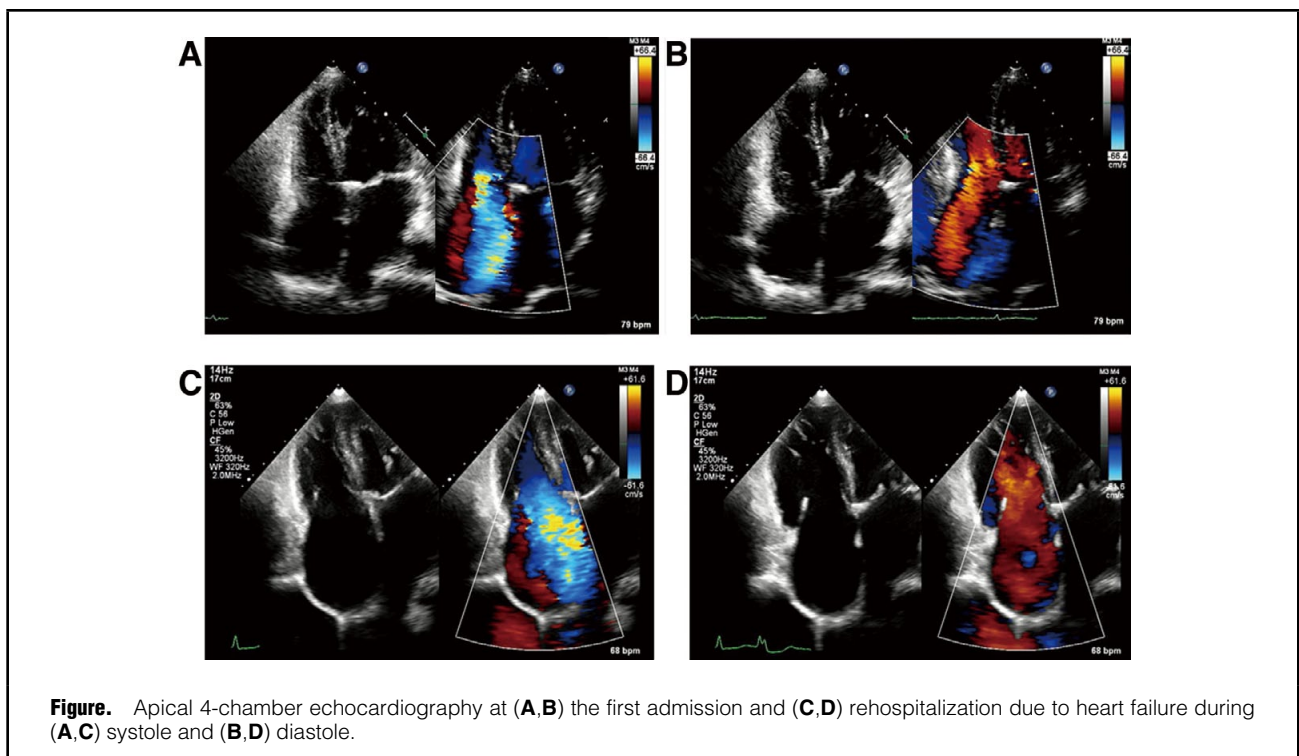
Apical 4-chamber echocardiography at (A,B) the first admission and (C,D) rehospitalization due to heart failure during (A,C) systole and (B,D) diastole.
